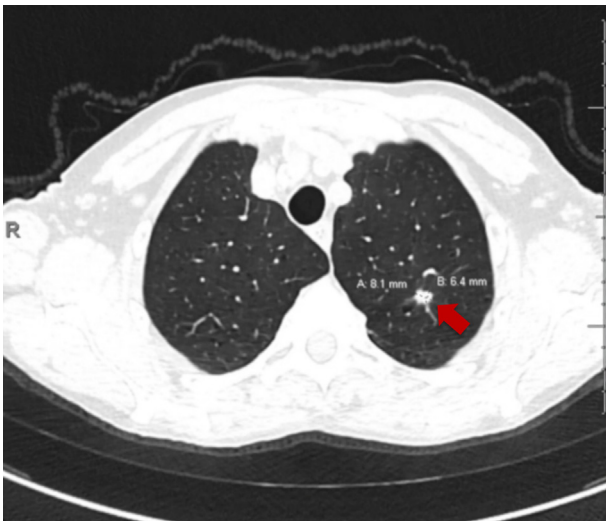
Chest computed tomography scan showing the nodule (arrow).
